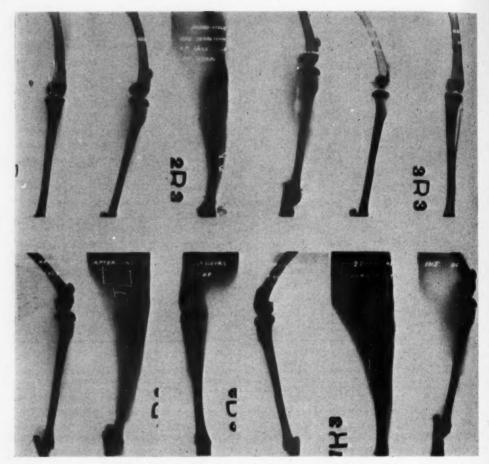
Serial radiographic follow-up of Experiment No. 3.
